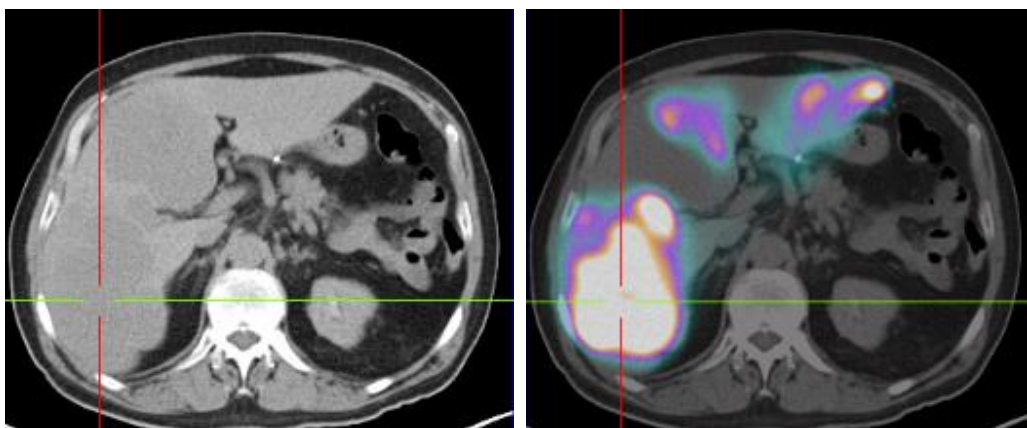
Pretreatment  $^{99\text{m}}\text{Tc}$ -MAA SPECT image.
